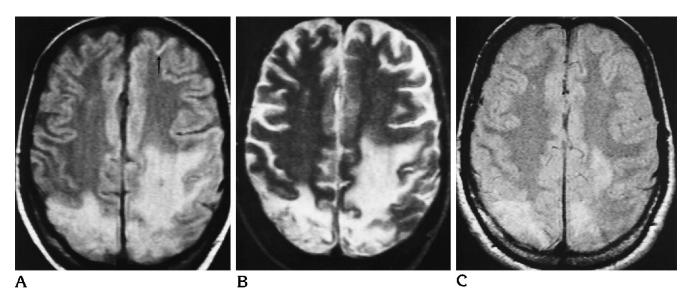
Patient 1: 40-year-old man with generalized seizures, right hemiparesis, and confusion 3 days after liver transplantation. A and B, Proton density–weighted (2200/20, A) and T2-weighted (2200/100, B) images show parietal cortical hyperintensities, fingerlike hyperintensities of the subjacent white matter associated with a space-occupying effect, and cortical hyperintensities in cingulate and frontal gyrus (*arrow*).
